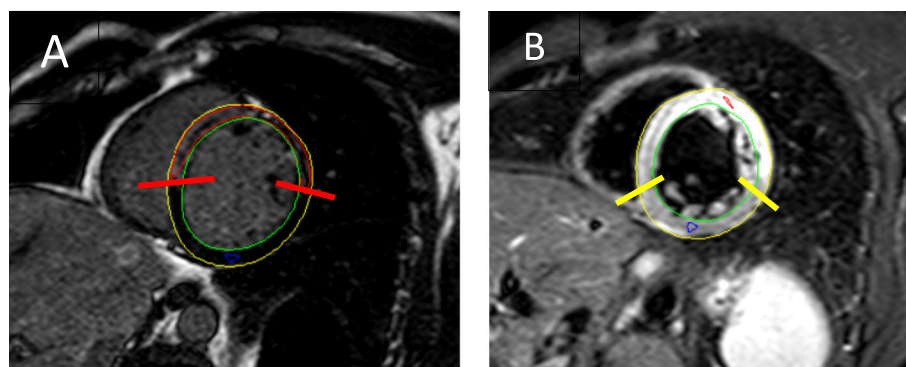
Cardiac MRI at 1 week in a patient with a large anterior myocardial infarction. a Late enhancement imaging allowed for the definition of infarct size (hyper-enhanced myocardium, between red arrows). B T2-weighted sequence demonstrated a large area at risk (with edema, between yellow arrows)
